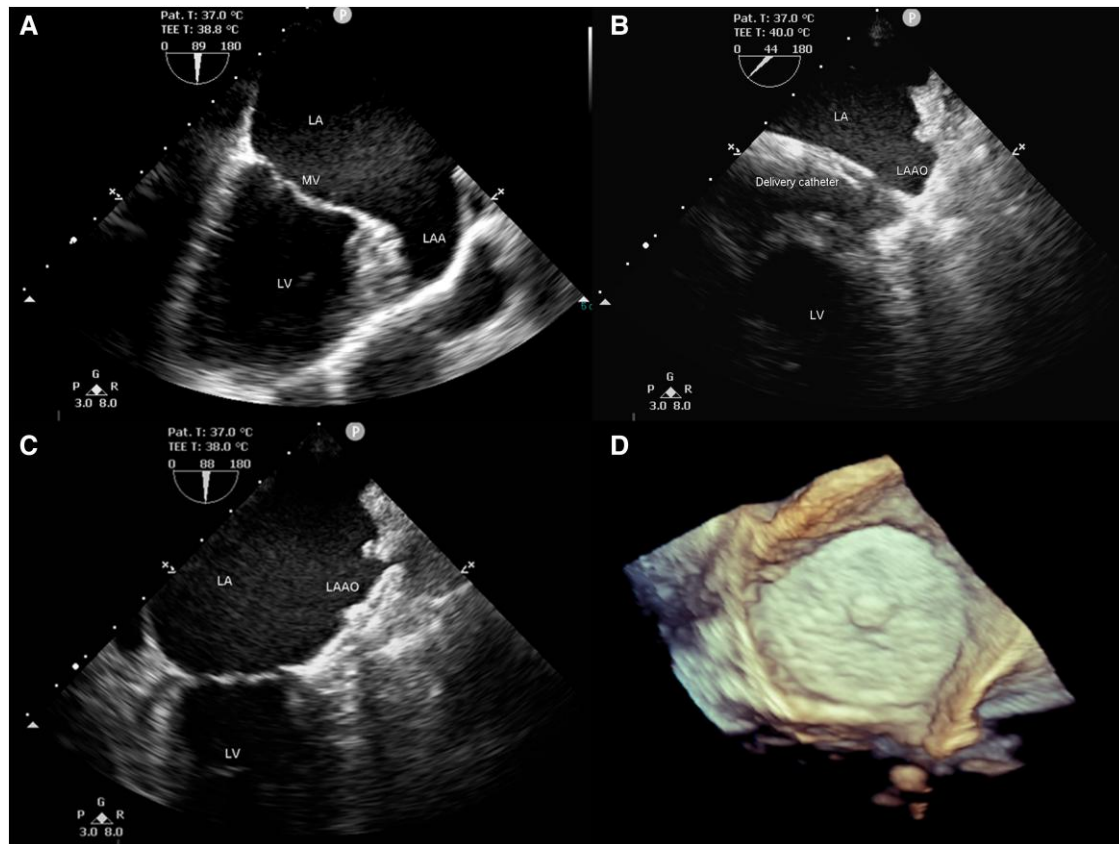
(A–C) Periprocedural transoesophageal echocardiogram. (A) Dilated left atrium and large left atrial appendage are seen with no residual thrombus. (B) The delivery catheter is seen in the left atrium pushing the occluder device (LAAO) into the left atrial appendage. (C) Final position of the LAAO at the end of the procedure. (D) Follow-up transoesophageal echocardiogram 6 weeks after the implantation of the LAAO. An enface 3D image of the LAAO and confirms that there is no thrombus on the device disk. LA, left atrium; LAA, left atrial appendage; LAAO, left atrial appendage occlusion; LV, left ventricle; MV, mitral valve. See also [supplementary videos 1–3](#).
